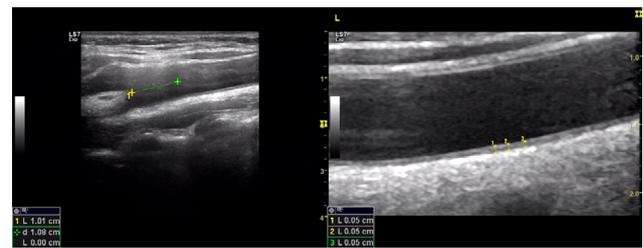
Measurement of common CIMT in carotid artery Doppler ultrasonography
